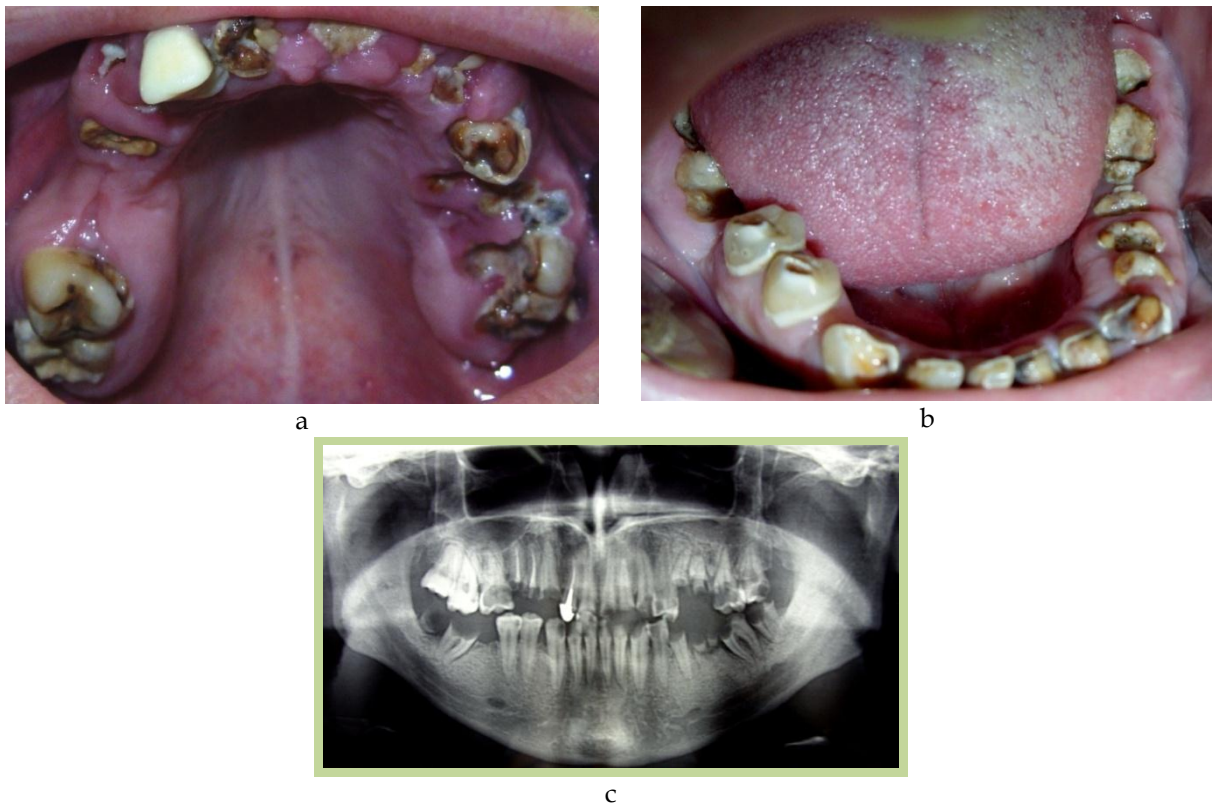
a. massive coronary destructions, loss of teeth; b. presence of demineralization injuries localized at the cervical level of the teeth; c. initial X-ray that shows the presence of multiple irrecoverable dental roots
